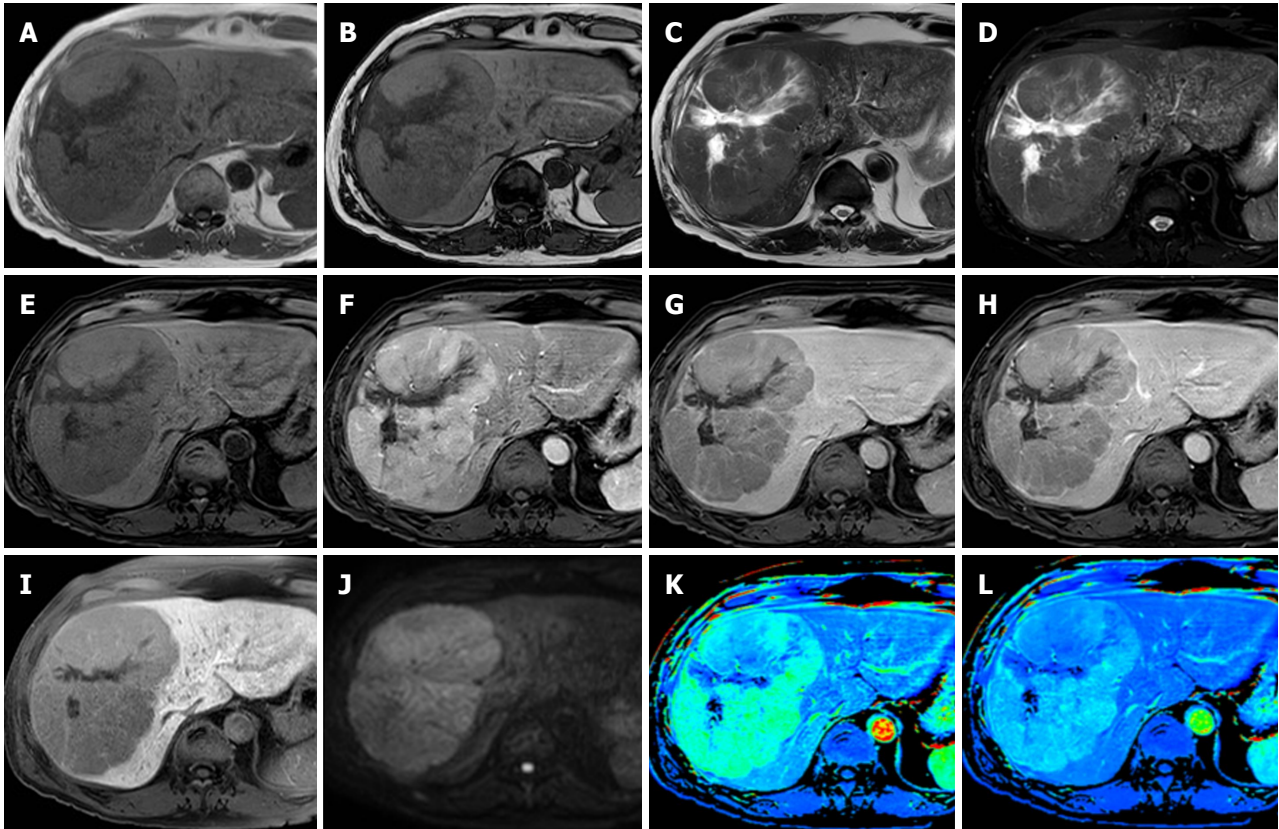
Gd-EOB-DTPA enhanced magnetic resonance images of a 67-year-old male patient with large hepatocellular carcinoma lesion in the right liver lobe. Panels A-B: T1-weighted sequences “in and out of phase” demonstrate a heterogeneous mass slightly hypointense without a signal drop in “out of phase” sequence. Panels C-D: T2-weighted image without and with fat saturation demonstrates a slightly hyperintense mass with a central, homogeneous hyperintense area, as per necrosis. Panels E-H: Dynamic contrast-enhanced images delineate the typical contrast behavior of hepatocellular carcinoma (HCC): Hyperenhancement during the arterial phase (F) followed by wash-out in portal and delayed phase (G-H). In the hepatobiliary phase image 20 min after Gd-EOB-DTPA injection the nodule appears highly hypointense compared with the surrounding enhanced liver (panel I). Panel J: On the diffusion weighted image, HCC lesion is hyperintense due to the restriction of water diffusion. Panel K-L: Perfusion images derived from semiquantitative analysis (relative arterial enhancement and maximum enhancement) the HCC is characterized by high vascularity intensity signals, shown as hot-spots signals.
